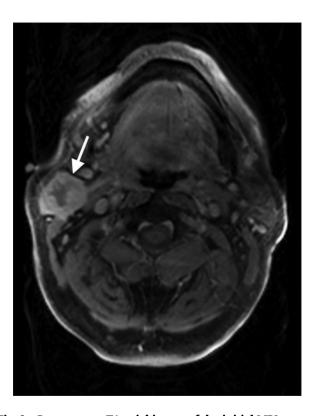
Postcontrast T1 axial image of the initial MRI examination. The right parotid mass enhances heterogeneously and demonstrates central necrosis and irregular borders. The contour suggests a malignant process.
